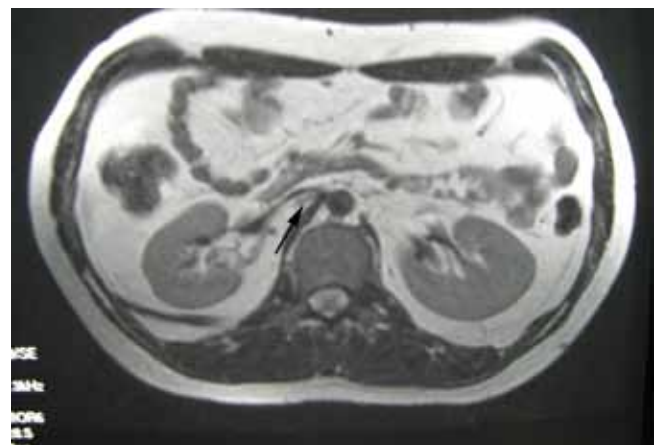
T2-weighted axial MRI showing apparent stenosis of IVC at renal level (Black Arrow).
